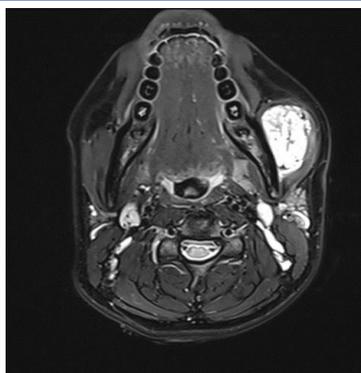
Axial and coronal contrast T2-weighted magnetic resonance imaging, showing a hyper-intense lesion within the masseter
